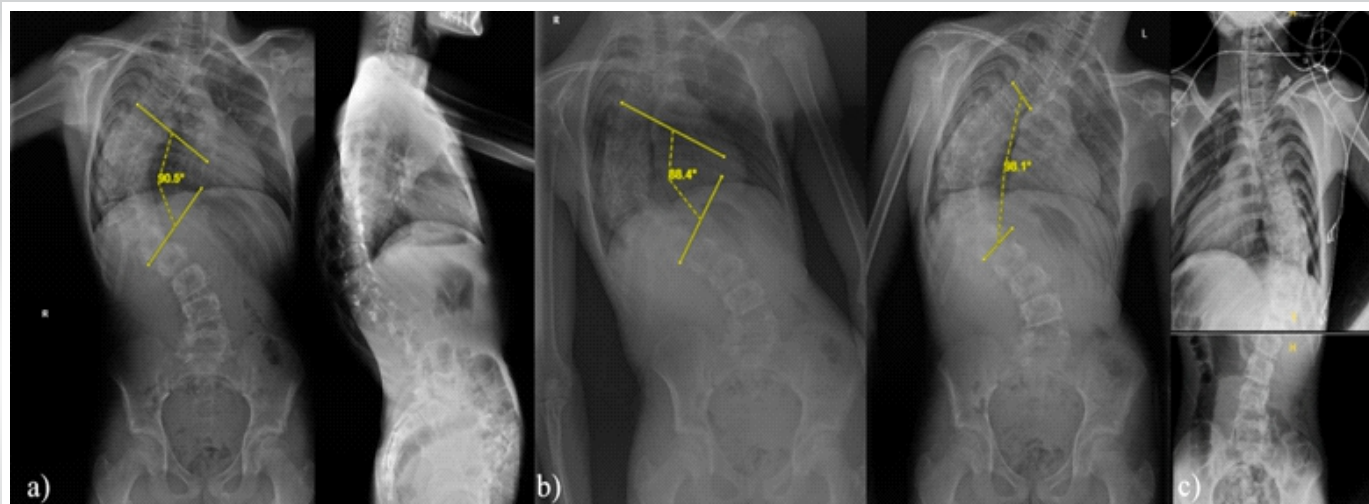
(a) Full-length upright scoliosis radiographs in the coronal and sagittal planes (standing anteroposterior/posteroanterior and lateral views), demonstrating a main thoracic curve with a Cobb angle of 90.5° and an apical vertebra at T10. (b) Full-length upright right and left lateral-bending radiographs obtained for assessment of coronal curve flexibility and surgical planning, with Cobb angles measuring 88.4° and 98.1°, respectively, and an apex at T10. (c) Intraoperative traction radiographs obtained under general anesthesia to assess deformity reducibility under controlled longitudinal traction. Pre-operative and intraoperative radiographic assessment of deformity and flexibility.
